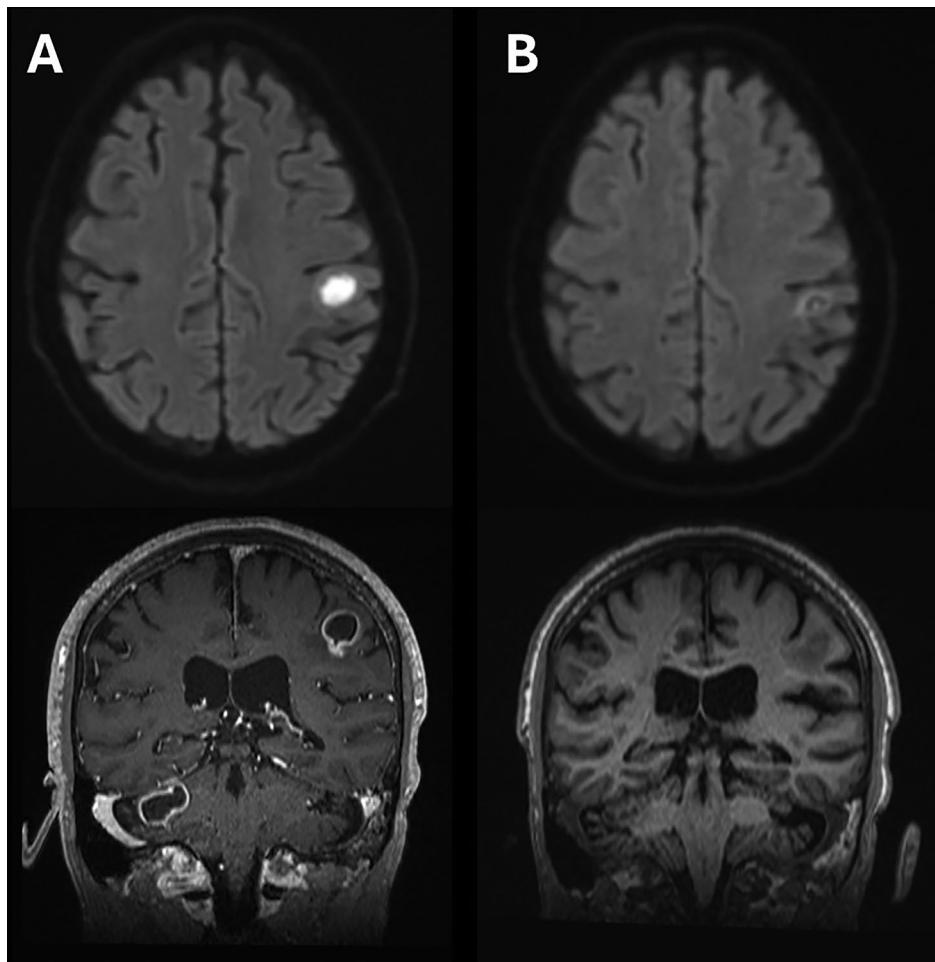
Pre-treatment and follow-up MRI brain imaging. Pre-treatment (A) and follow-up (B) MRI brain imaging, 6 weeks apart. Contrast was not used in the follow-up imaging due to concerns about graft function. The axial images, top, are diffusion-weighted and show reduction of the diffusion restriction within the post-central gyrus abscess. The coronal images, bottom, are T1 weighted and show collapse of the right cerebellar and post-central gyrus abscesses
